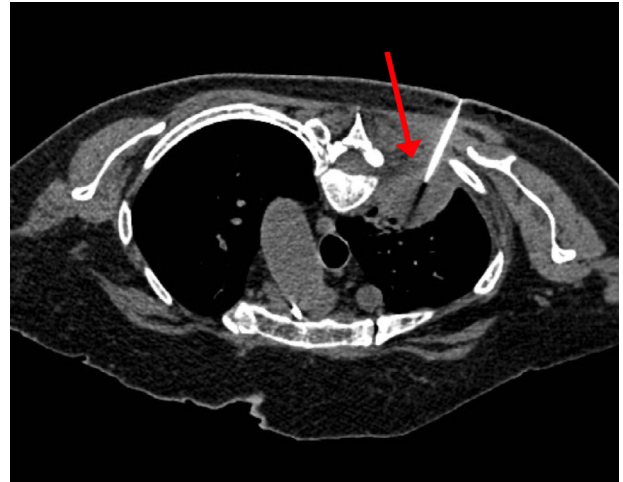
non-enhanced CT guided biopsy of right upper lobe posterior cavitary mass (arrow). The image demonstrates the biopsy needle tract away from the spinal canal.
